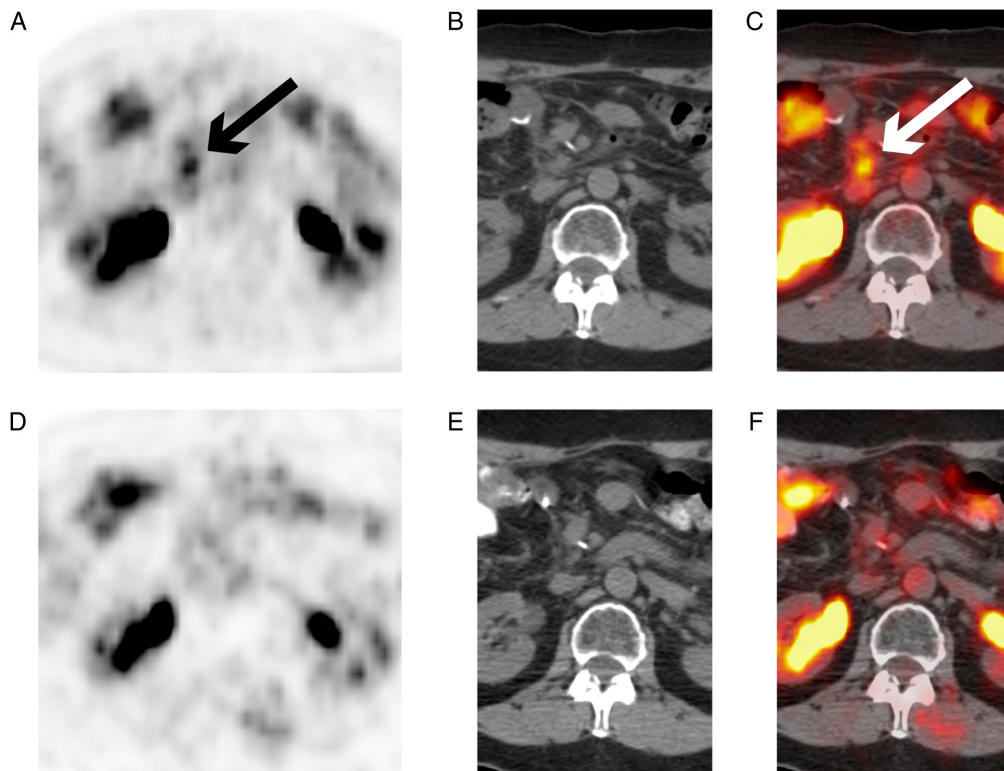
Resolution of FDG-glucose uptake in a metastatic lymph node following DeltaRex-G therapy. (A) Prior to DeltaRex-G treatment, avid uptake of FDG-glucose was observed in the metastatic lymph node by PET alone (arrow). (B) These observations were not readily seen by CT alone. (C) Avid uptake of FDG-glucose was also noted by PET-CT (arrow). (D) After treatment with DeltaRex-G, no FDA-glucose uptake was observed by PET. (E) These observations were not readily seen by CT alone. (F) After treatment with DeltaRex-G, no FDA-glucose uptake was observed by PET-CT. FDG, fluorodeoxyglucose; PET, positron emission tomography; CT, computerized tomography.
